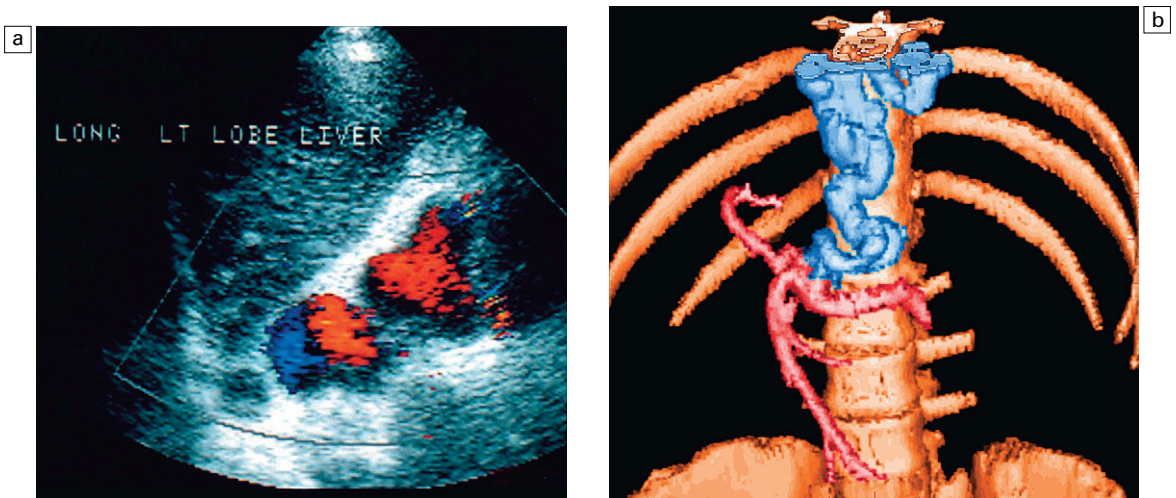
(a) Longitudinal colour Doppler image in the midline of a patient with portal hypertension. A large tortuous left gastric varix is seen coursing from the region of the coeliac axis towards the gastro-oesophageal junction. Whereas short gastric varices tend to be a plexus of small vessels, the left gastric varix is typically a single large tortuous vessel. (b) Coloured shaded surface displays three-dimensional reconstruction of the portal vasculature. The portal venous system is coloured red. The vessel represents a large left gastric varix. Note the convoluted nature of this vessel as it courses cephalad, eventually branching into multiple oesophageal varices.
